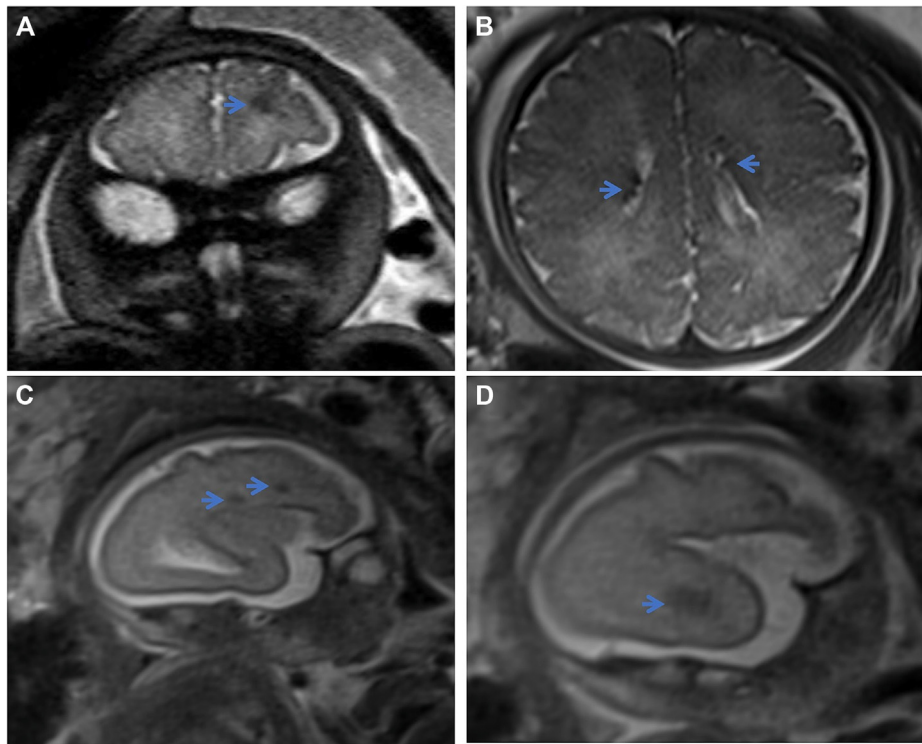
TSC-related MRI characteristics on fetal MRI. A, Fetus gestational age 33 weeks, coronal T2-weighted image with (sub)cortical lesion. B, Fetus 37 weeks, axial T2-weighted image with multiple subependymal nodules. C and D, Fetus gestational age 26 weeks. Sagittal T2-weighted image with (sub)cortical lesions. C, Small lesion (<5 mm) left frontal lobe. D, Large lesion (>5 mm) left temporal lobe. Abnormalities are indicated with arrowheads.
